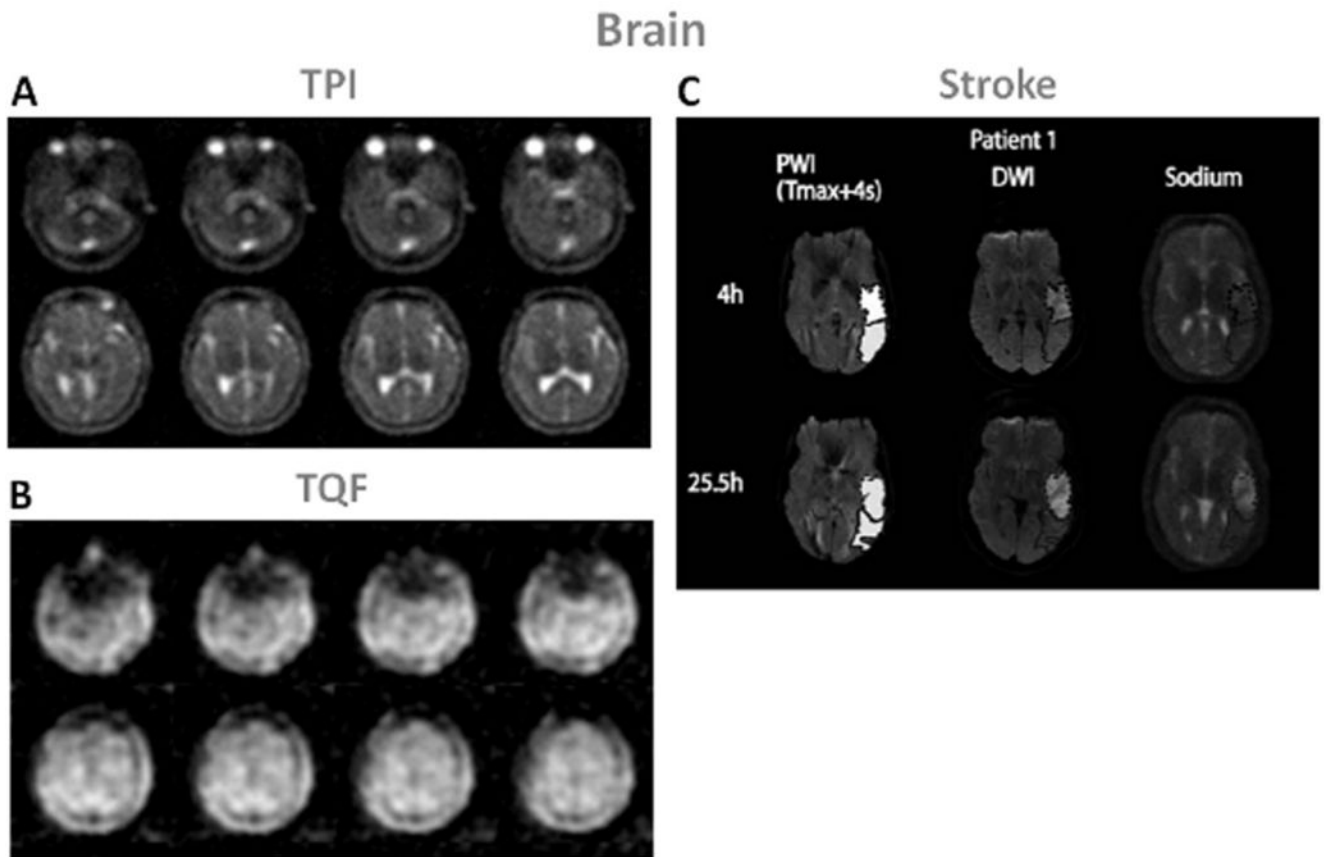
Examples of brain images. A: Twisted projection imaging (TPI) at 3T of a healthy brain. B: Triple-quantum filtered (TQF)-TPI at 3T of a healthy brain. C: Representative perfusion weighted imaging (PWI), diffusion weighted imaging (DWI) at 1.5T and sodium TPI at 4.7T of the brain of a patient with acute ischemic stroke. These images show the hypoperfused (Tmax+4s) perfusion maps, the DWI hyperintense (core) in dotted outline and the PWI-DWI mismatch tissue (penumbra) in solid outline, and corresponding sodium images, acquired 4h and 25.5h after symptom onset. Figures A and B: Courtesy of Professor F. Boada, New York University Medical Center / University of Pittsburgh Medical Center. Figure C from Tsang A. et al. *J Magn Reson Imaging* 33:41–47, 2011. Reproduced by permission of Wiley-Blackwell.
